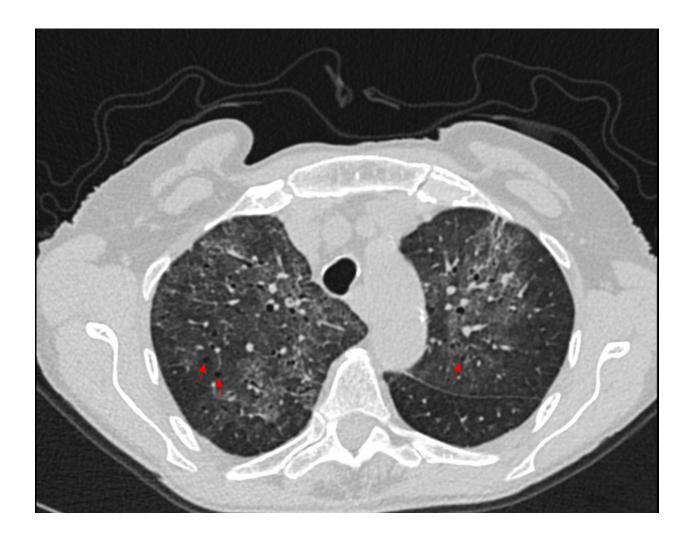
Chest Computed Tomographic (CT) Image. Representative axial image from the patient's chest CT scan. Red arrows indicate cystic changes.
